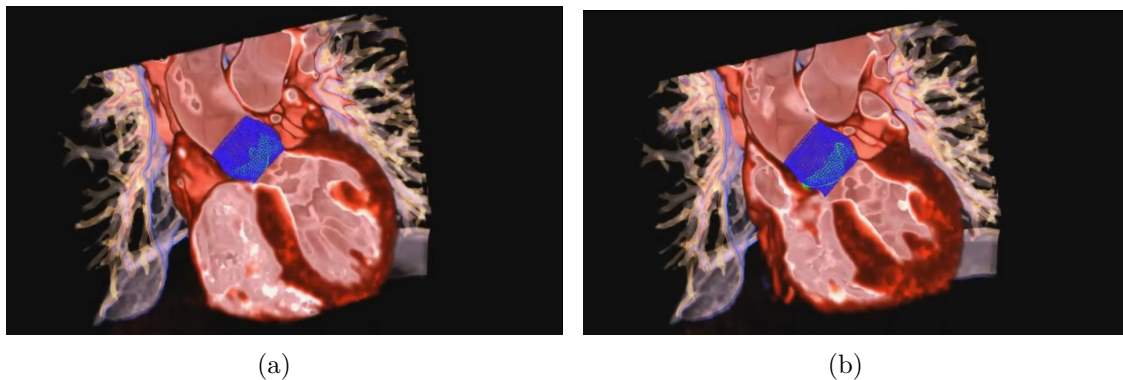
Exemplary rendering of two 3D volume frames from a ten frame 4D CTA dataset of the human heart. Inside DVR a mesh representation of a automatically extracted aortic valve model [80] is rendered. Contrast inside vessels and heart chambers is removed by a combination of 3D volume filtering and pre-integration during ray-casing.
